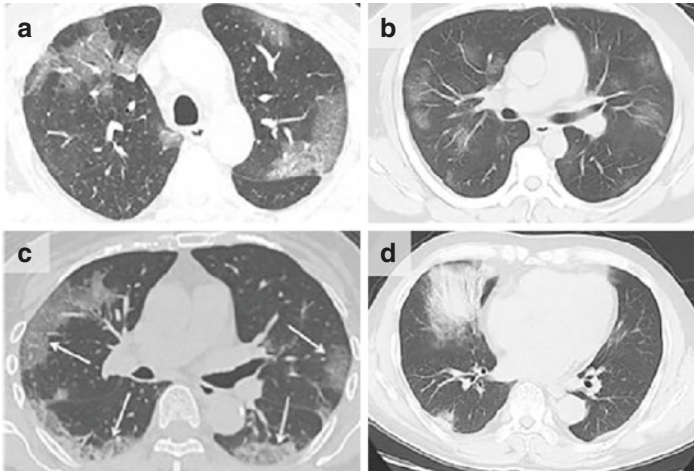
Typical CT findings of COVID-19: (a) multiple patchy areas of pure ground-glass opacity (GGO) and GGO with reticular and/or interlobular septal thickening; (b) multiple patches, grid-like lobule, and thickening of interlobular septa, typical “paving stone-like” signs; (c) bilateral ground-glass and consolidative opacities with a striking peripheral distribution; and (d) large consolidation in the right middle lobe, patchy consolidation in the posterior and basal segment of the right lower lobe, with air bronchogram inside*. *Imaging from Wenjing Yang, Arlene Sirajuddin, Xiaochun Zhang, The role of imaging in 2019 novel coronavirus pneumonia (COVID-19), *Eur Radiol* 2020 (Copyright © European Society of Radiology 2020: This article is made available via the PMC Open Access Subset for unrestricted research re-use and secondary analysis in any form or by any means with acknowledgement of the original source. These permissions are granted for the duration of the World Health Organization (WHO) declaration of COVID-19 as a global pandemic)
